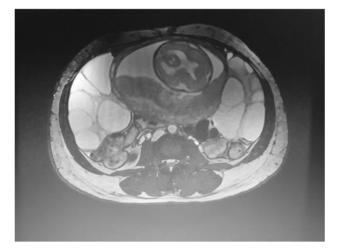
MRI pelvis showing bilateral adnexa with multicystic lesions of 15 cm size and a singleton pregnancy
